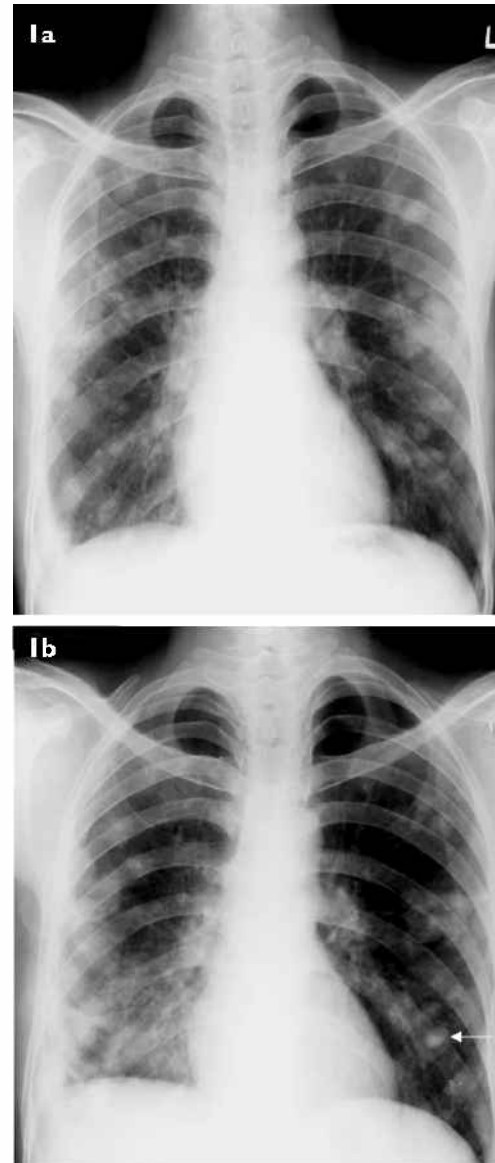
Chest radiograph (posteroanterior view) taken (a) pre-treatment shows multiple well-defined nodules distributed randomly in bilateral lung fields. (b) Post-treatment radiograph shows a decrease in number of nodules and appearance of calcification (arrow).
